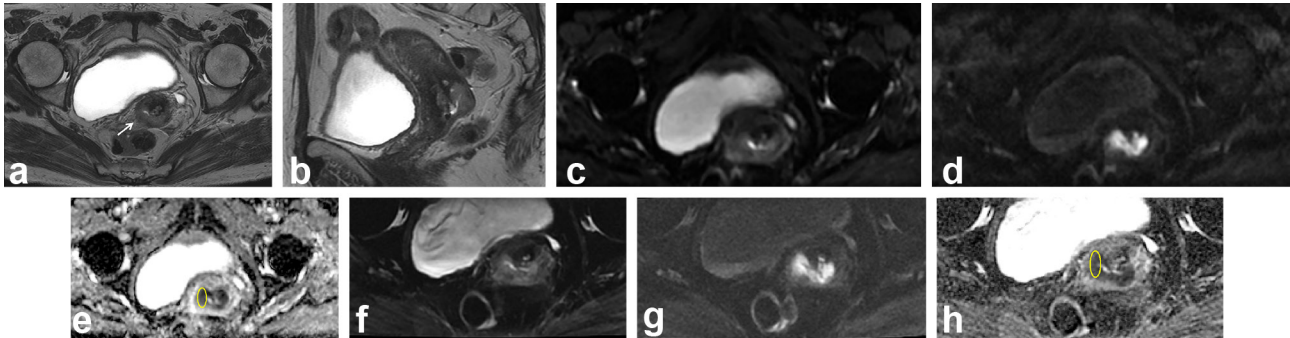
A 58-year-old female with International Federation of Gynecology and Obstetrics stage IBI squamous cell carcinoma of the cervix. (a, b) Axial and sagittal T_2 weighted images show an intermediate signal intensity cervical mass with interruption of the cervical stromal ring in the right side, without definite extracervical extension (arrow). (c-e) Conventional DWI at $b = 0 \text{ s mm}^{-2}$, $b = 1000 \text{ s mm}^{-2}$, and corresponding ADC map with placement of ROI. The ADC value of the lesion is $0.945 \times 10^{-3} \text{ mm}^2 \text{ s}^{-1}$. (f-h) Reduced FOV DWI at $b = 0 \text{ s mm}^{-2}$, $b = 800 \text{ s mm}^{-2}$, and corresponding ADC map with placement of ROI. The ADC value of the lesion is $0.915 \times 10^{-3} \text{ mm}^2 \text{ s}^{-1}$. Compared with conventional DWI, reduced FOV images show the lesion with a clear border and fewer artifacts. ADC, apparent diffusion coefficient; DWI, diffusion-weighted imaging; FOV, field-of-view; ROI, region of interest.
